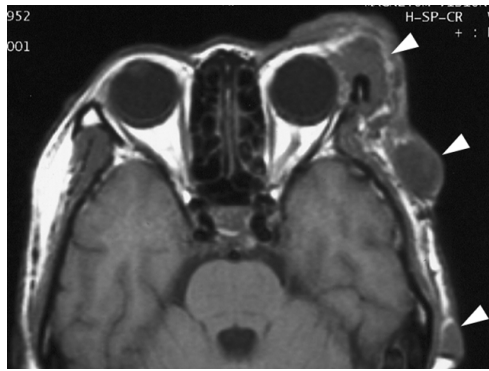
Plexiform neurofibromatosis in a 66-year-old man. The T1-weighted axial image shows multiple lobulating masses involving the left lacrimal fossa and the subcutaneous layer of the left temporal region (arrowheads).
